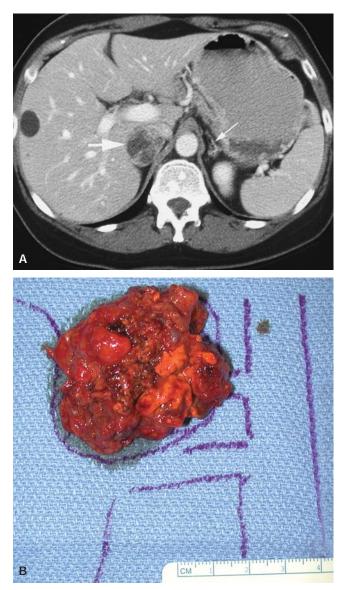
A 47-year-old woman had a 2 cm right adrenal tumor discovered incidentally 2 years ago and had a negative biochemical workup. *A*, A follow-up abdominal computed tomographic scan 2 years later showed the right adrenal tumor (*large white arrow*) to have grown to 3.5 cm. The left adrenal gland (*small white arrow*) was normal. Biochemical workup again showed no hyperfunction. She underwent a laparoscopic right adrenalectomy. *B*, Pathology showed it to be a adrenocortical adenoma.
